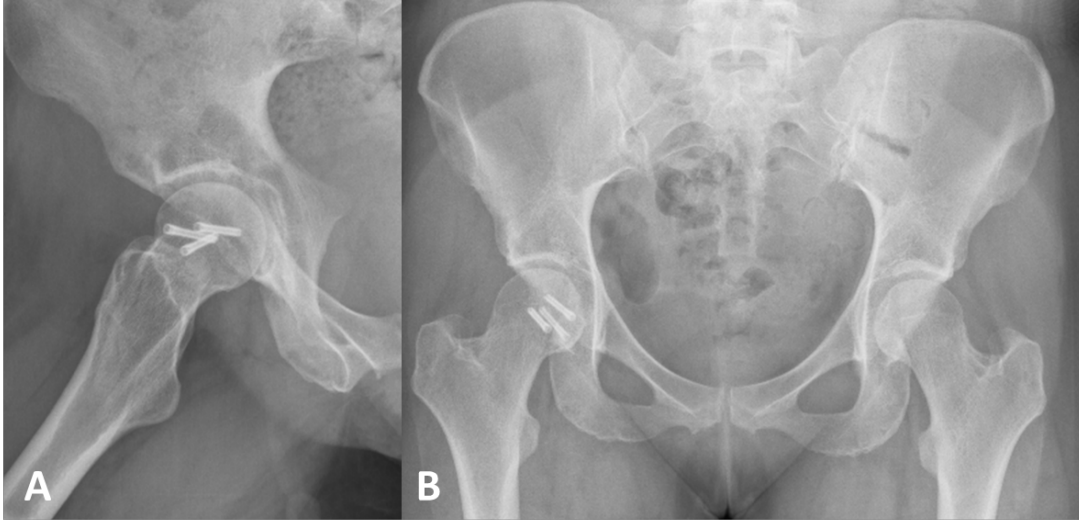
One-year post-operation radiographs demonstrating healed femoral head fracture with three cannulated screws in-situ. No heterotopic ossification or avascular necrosis is noted.
